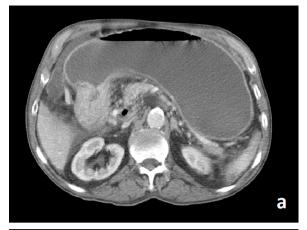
(a) Axial CT scan showing gastric distention and increased gastric wall thickness in the pyloric region; aeroportia can also be seen in this picture. (b) Left arrow shows thrombus and air in the portal vein, right arrow shows thrombosis in the splenic vein; arrowhead shows contrast in the splenic vein before the thrombus.
